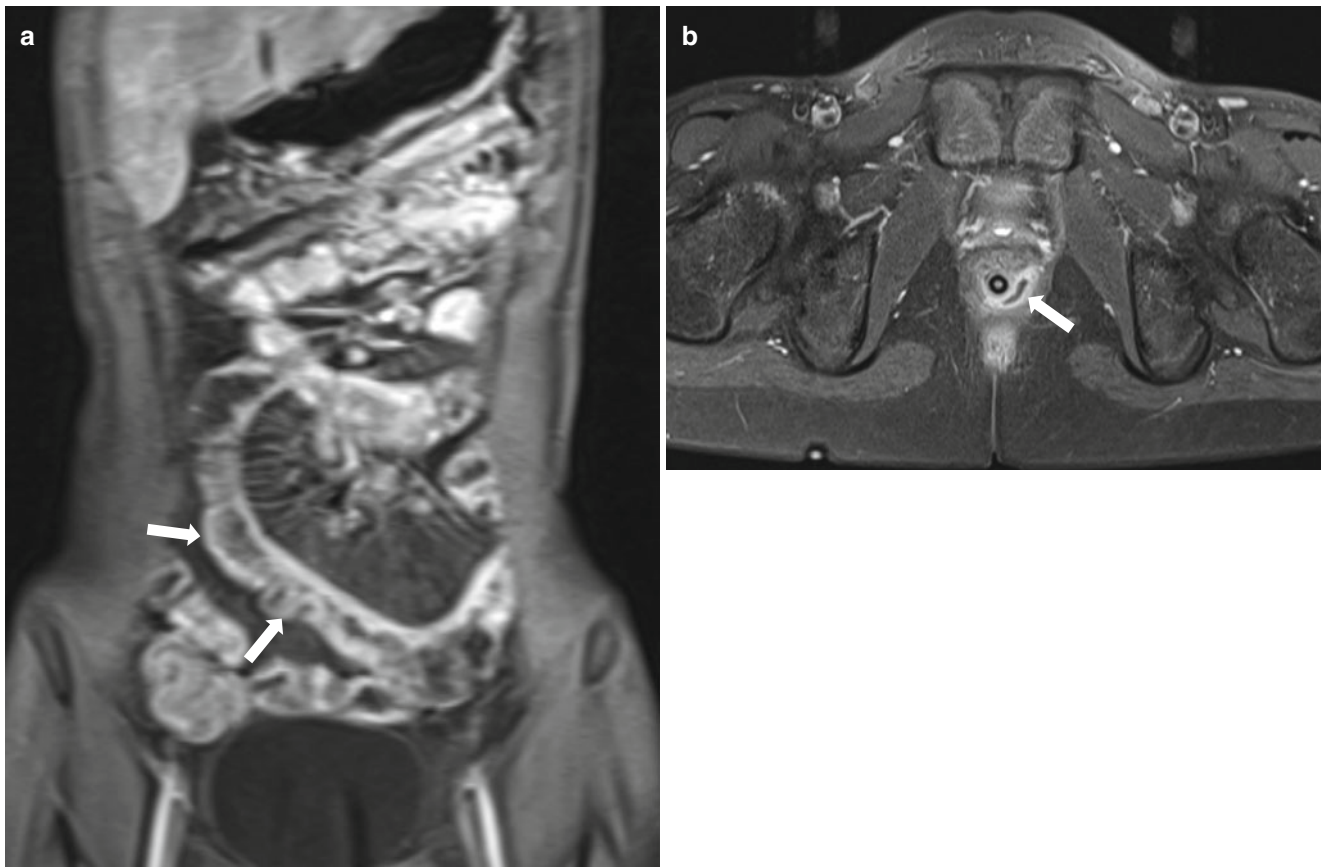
Crohn disease: MR enterography. (a) Coronal view of contrast-enhanced T1-weighted image of a 19-year-old male demonstrates mucosal hyperenhancement and engorged vasa recta of the small bowel segments indicating active inflammation. Note the pseudosacculation
